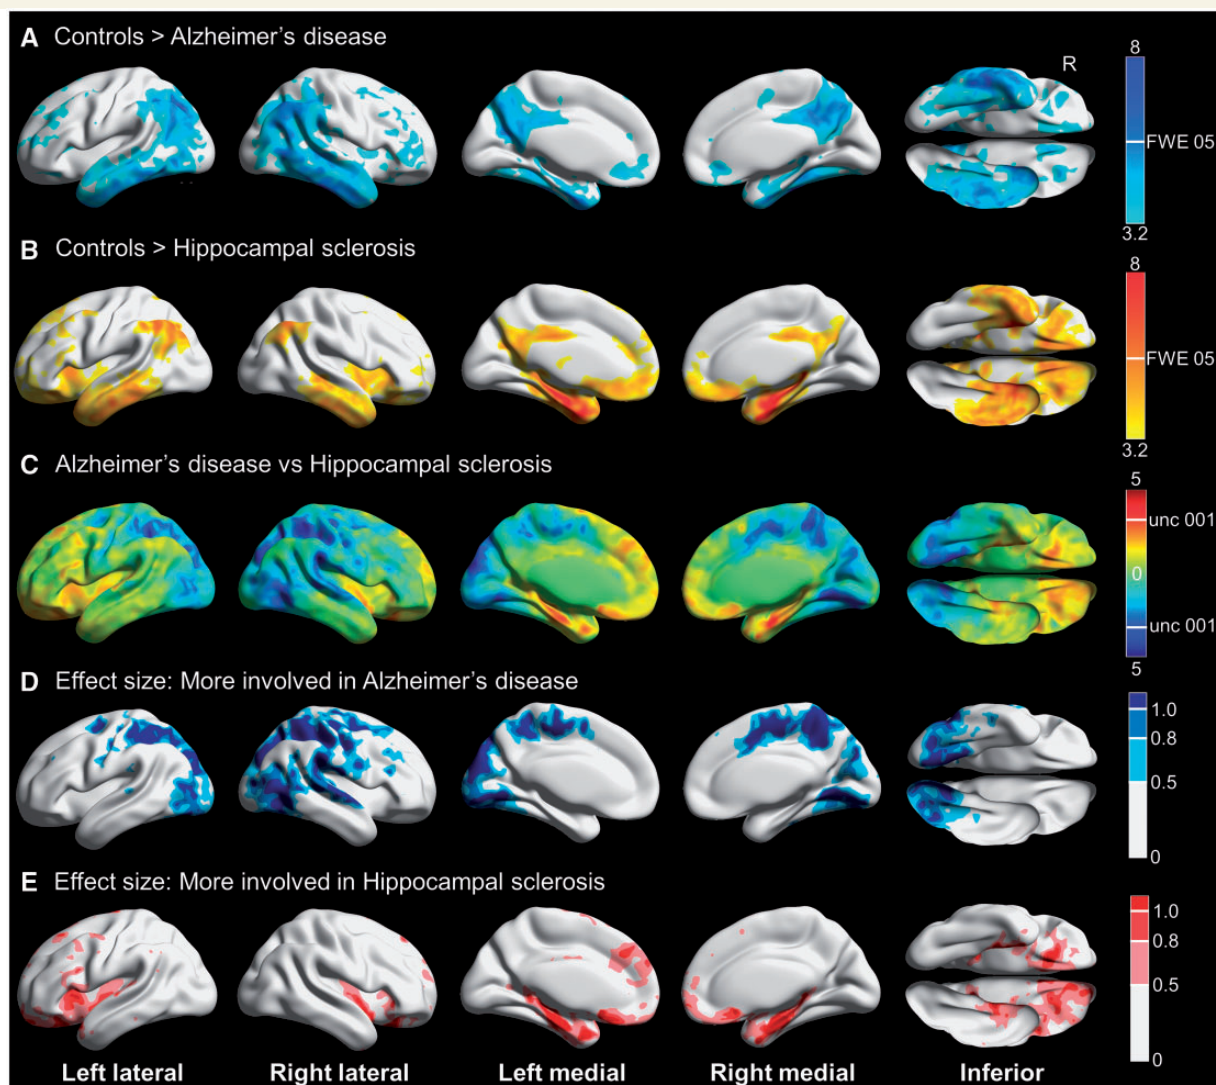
3D brain renderings showing results of FDG-PET analysis in hippocampal sclerosis and Alzheimer's disease participants. (A) Compared to controls, TDP-43 negative Alzheimer's disease was associated with hypometabolism of the posterior cingulate, middle and inferior temporal and lateral and medial parietal regions including the precuneus. There was minimal medial temporal involvement. Results are shown at $P(\text{unc}) = 0.001$ with the height cut-off for FWE correction shown in the colour bar. (B) Compared to controls, TDP-43-positive hippocampal sclerosis was associated with hypometabolism predominantly in the medial temporal lobe, with additional involvement of the middle and inferior temporal, lateral parietal and insular regions. Results are shown at $P(\text{unc}) = 0.001$ with the height cut-off for family-wise error (FWE) correction shown in the colour bar. Note that most hippocampal sclerosis cases had concomitant Alzheimer's disease. (C) T-map for hippocampal sclerosis compared to Alzheimer's disease, with red-yellow indicating regions more involved in hippocampal sclerosis and blue-cyan showing areas more involved in Alzheimer's disease. There was more medial temporal and orbitofrontal involvement in hippocampal sclerosis, and more posterior-inferior temporal, occipital and parietal involvement in Alzheimer's disease. (D) Effect size (Cohen's d) map for the direct comparison showing areas of greater involvement in Alzheimer's disease, including moderate (0.5–0.8) to large (>0.8) effect sizes for the posterior-inferior temporal, occipital and parietal regions. (E) Effect size (Cohen's d) map for the direct comparison showing areas of greater involvement in hippocampal sclerosis, including moderate (0.5–0.8) to large (>0.8) effect sizes for the medial temporal and orbitofrontal regions. Renders created using Brain Net Viewer (Xia *et al.*, 2013) (<https://www.nitrc.org/projects/bnv/>).
